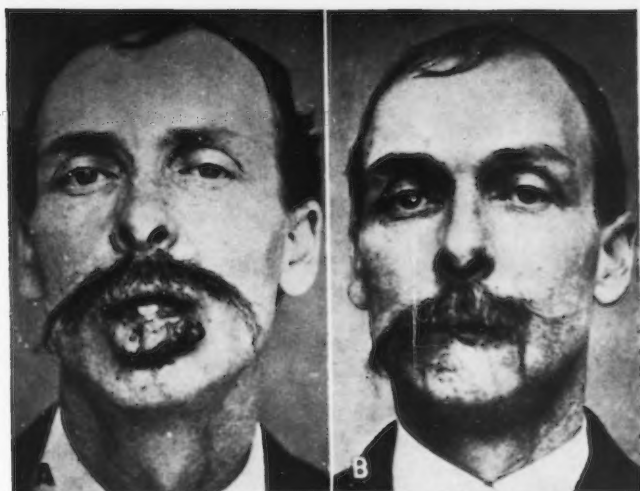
A, Male, age 41; cancer of the lip of eleven years' duration; began as a fever blister. He had previously been treated with caustics by a layman. Roentgen-ray treatment began May 25, 1903. B, The patient remained well thirty years and died of intercurrent disease.
